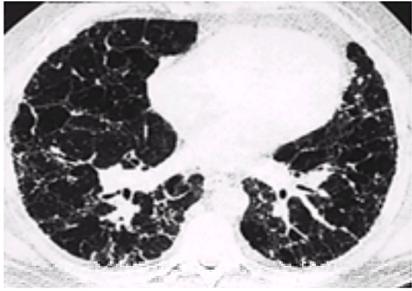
High resolution computed tomogram of lung in advanced stages of pulmonary eosinophilic granuloma shows extensive cystic changes.
